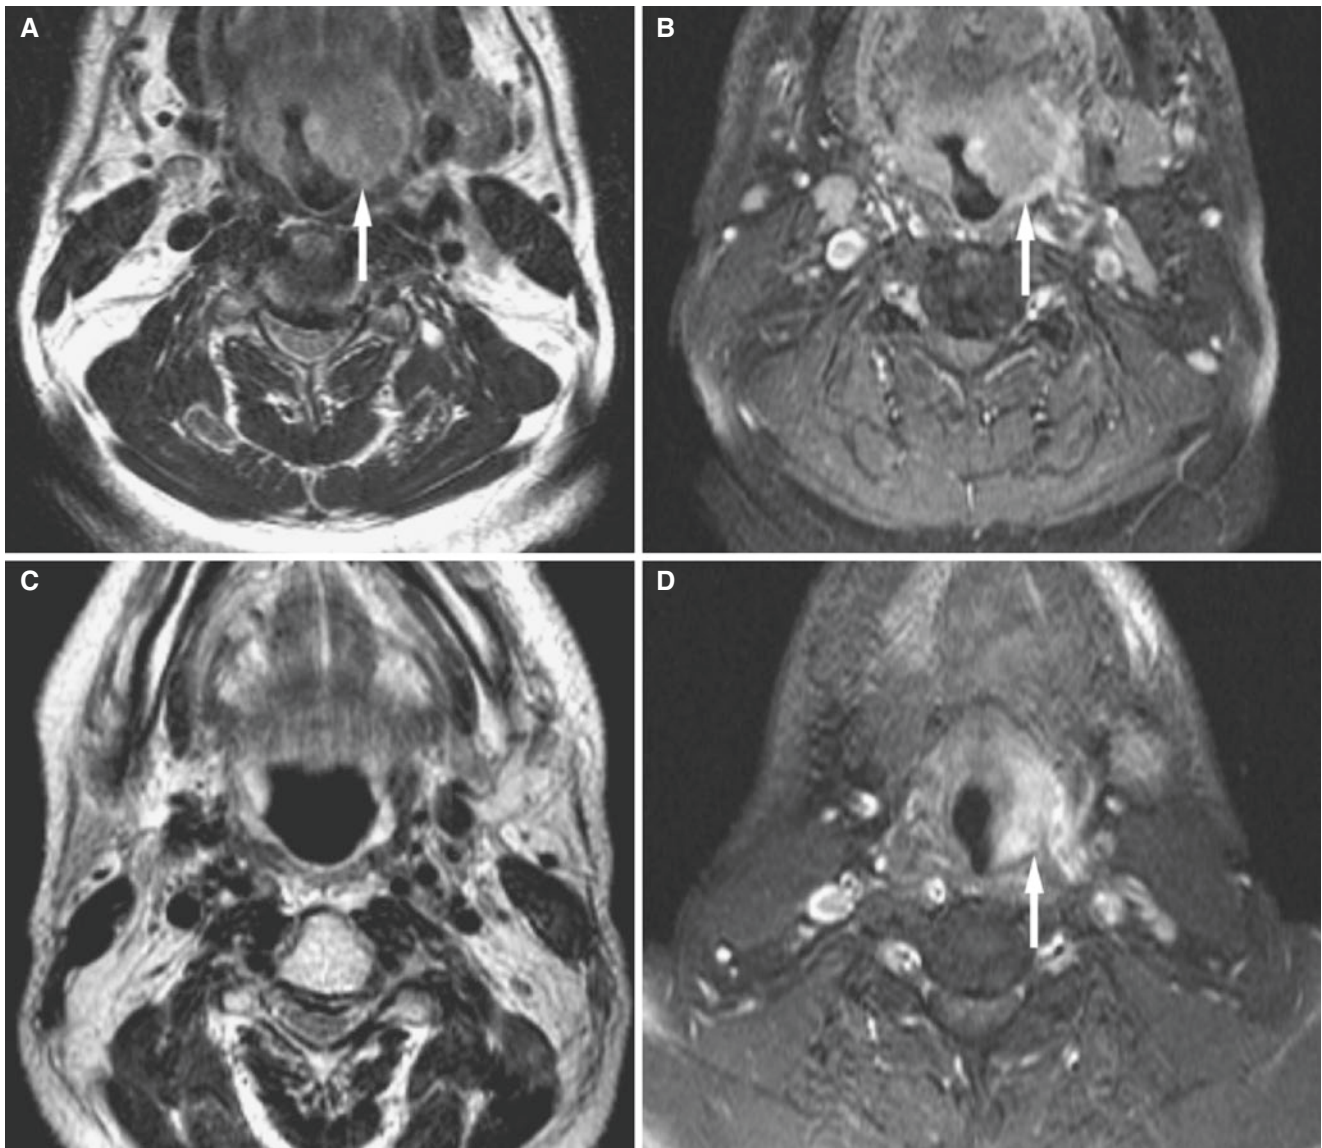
Tongue base carcinoma; 64-year-old man presents with left throat pain. (A) Axial T2-weighted MRI shows a large low intensity mass in left tongue base extending to the hypopharynx (*arrow*). The signal is higher than muscle but still not bright. (B) Axial T1-weighted
